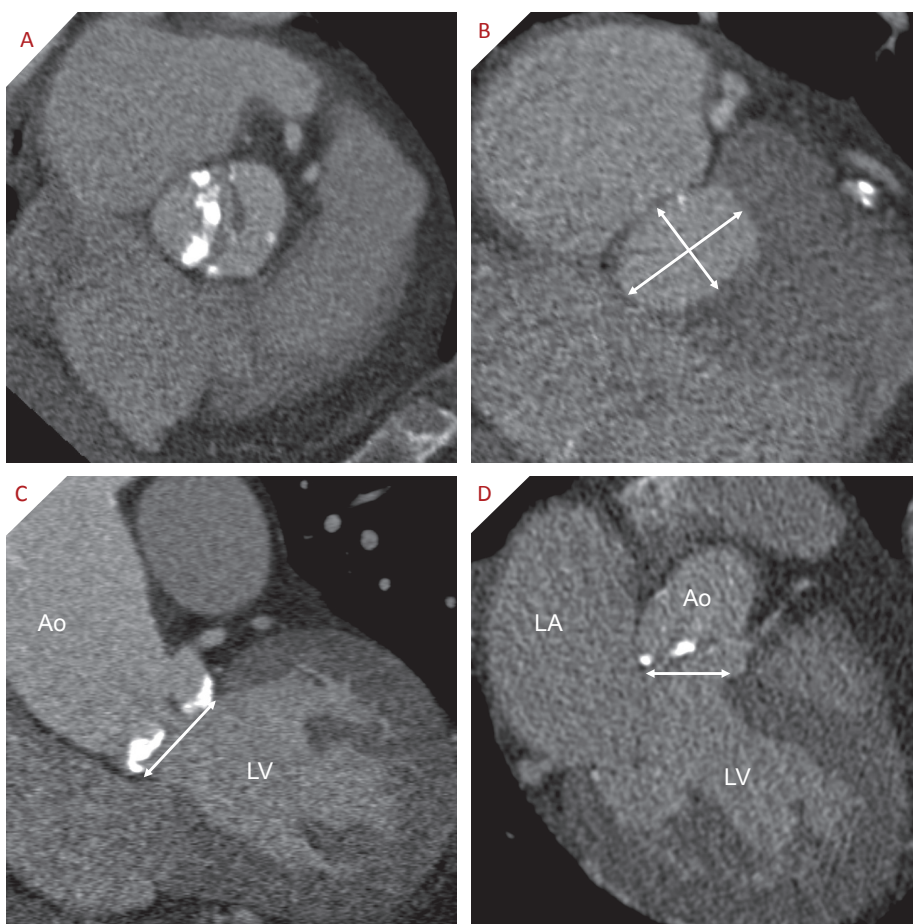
Assessment of the aortic valve annulus by multi-slice computed tomography. Oblique transverse view allows assessment of the degree of calcification of (A) the aortic valve (which in this case is functionally bicuspid), and (B) the oval shaped annulus size. The size of the aortic valve annulus is measured in the (C) coronal and (D) sagittal views, providing an estimation of the eccentricity of the aortic valve annulus.
